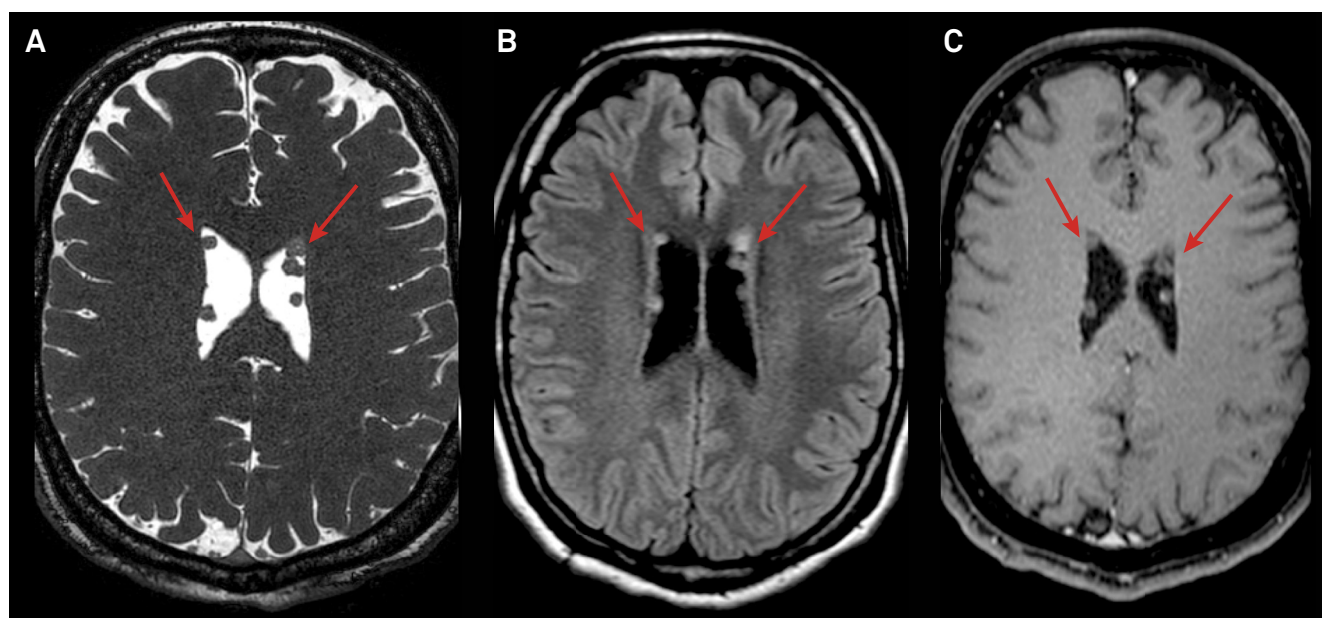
MRI, axial balanced, a three-dimensional steady-state free precession T2-weighted imaging (A), FLAIR (B) and T1-post gadolinium (C), obtained at the level of the roof of the lateral ventricles show ring-shaped left lateral ventricular nodules (arrows) with no contrast enhancement.
